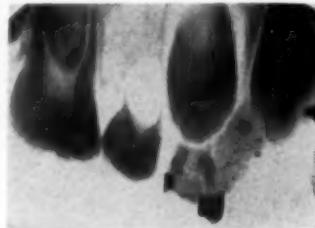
Intraoral roentgenogram of a permanent upper second premolar literally "jumping" into occlusion due to the premature loss of its deciduous predecessor. Note the lack of root formation; the dentine growth and pulpal constriction; the failure of the alveolar bone to keep up with the tooth; and the wide periapical space between tooth and bone. Compare with the first premolar which normally precedes the second in its eruption.
